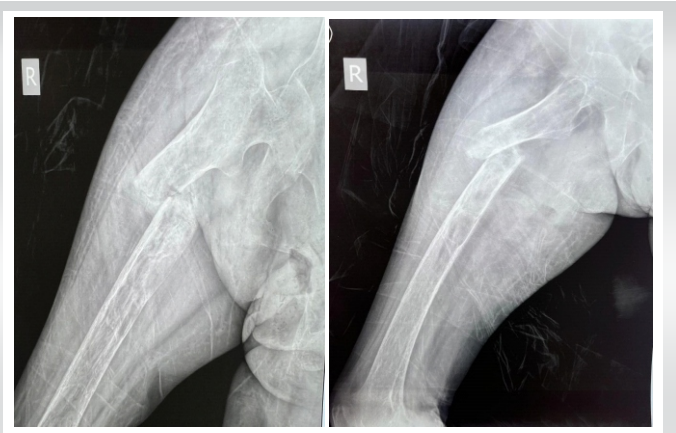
Radiographs of right hip at presentation (Antero-posterior and lateral views) showing pathological right subtrochanteric femur fracture.
